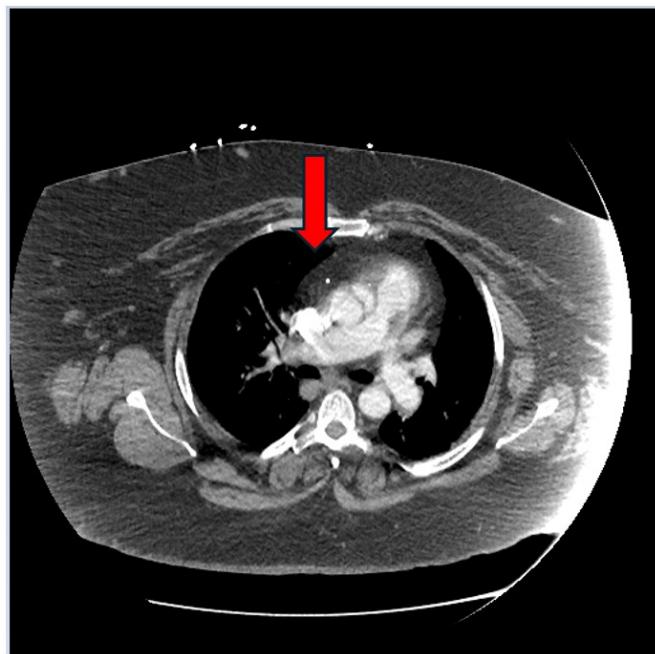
Contrast CT images in transverse plane consistent with false lumen flap (red arrow), a finding consistent with aortic dissection. Imaging is also remarkable for thicker than normal subcutaneous tissue and fat.
